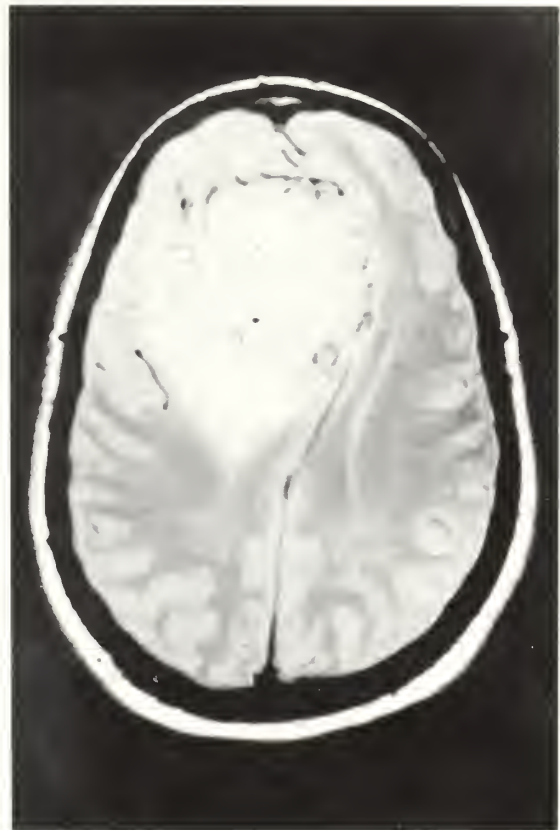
MRI scan showing frontal meningioma with midline shift.
